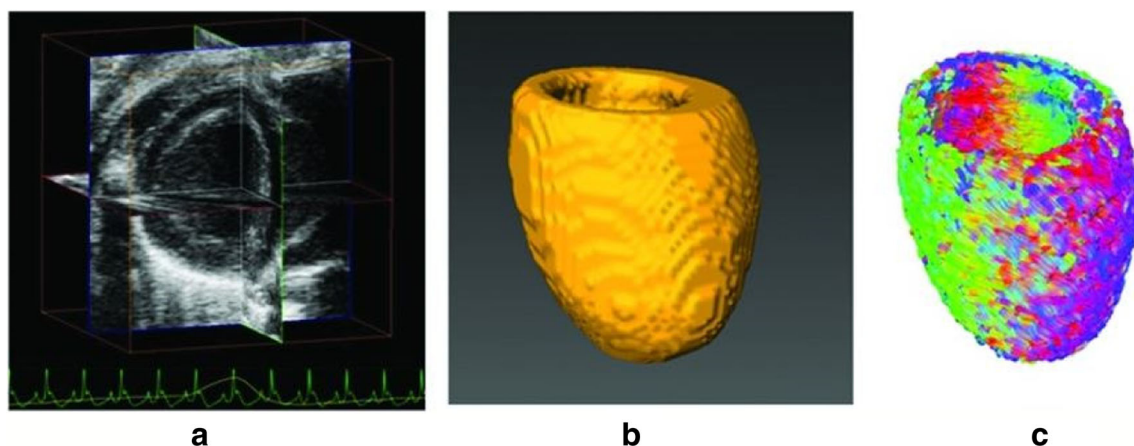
Cardiac fiber orientation estimation of an *in vivo* beating heart. a 3D ultrasound volume *in vivo*. b Reconstructed cardiac geometry. c Estimated cardiac fiber orientations from the geometry. Image adapted from [47]
